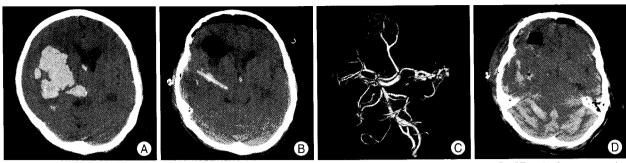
A: Acute intracerebral hemorrhage in the right basal ganglia along with intraventricular hemorrhage on admission. B: CT on the first postoperative day; most of the hematoma has been removed, and pneumocephalus is present; there are no abnormal findings in the posterior fossa. C: No definite pathologic findings were detected on CT angiography D: RCH spreading over both cerebellar hemispheres and the vermis on CT, 3 days after surgery. RCH: remote cerebellar hemorrhage.
